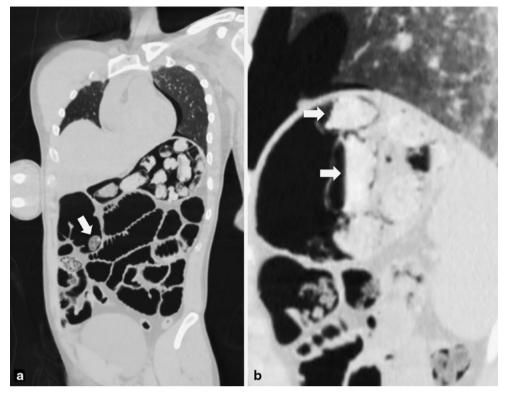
Postmortem computed tomography. a Angulated coronal CT image in the lung window depicting the variable drug packages in the stomach and the sole one in the transverse colon (*white arrow*).
